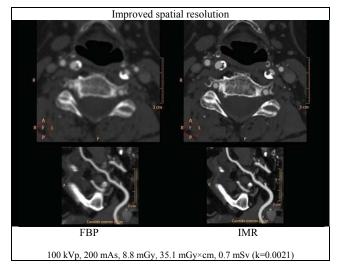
A carotid CT angiogram on a Philips iCT at 0.7mSv (100 kVp, 200 mAs, 8.8 mGy, 35.1 mGy×cm), reconstructed using FBP (left) and IMR (right). Study shows limited resolution on FBP, at a given noise target. IMR significantly improves spatial resolution, and at the same time lowers noise. Courtesy of UCL, Belgium.
